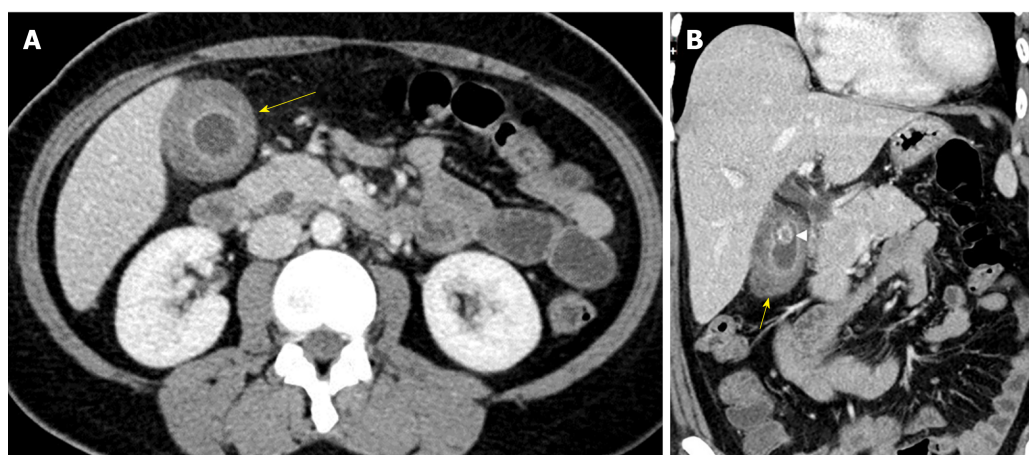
Contrast enhanced computed tomography of the abdomen and pelvis. A: Thickened gallbladder wall (arrow) with moderate increased density of the submucosa; B: Reformatted contrast enhanced computed tomography showing heterogeneous density of the gallbladder wall (arrow). A calculus (arrowhead) is present within the gallbladder.
